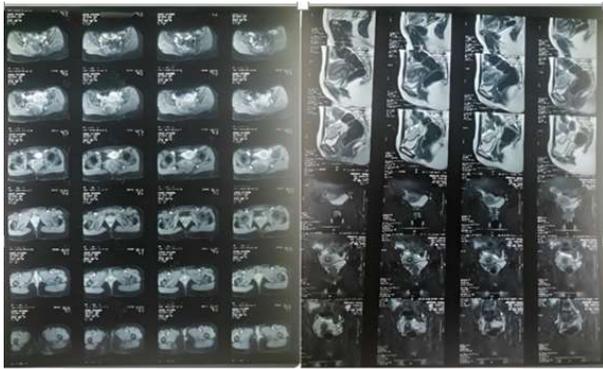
Pelvic MRI showing the perineal endometriotic nodule
